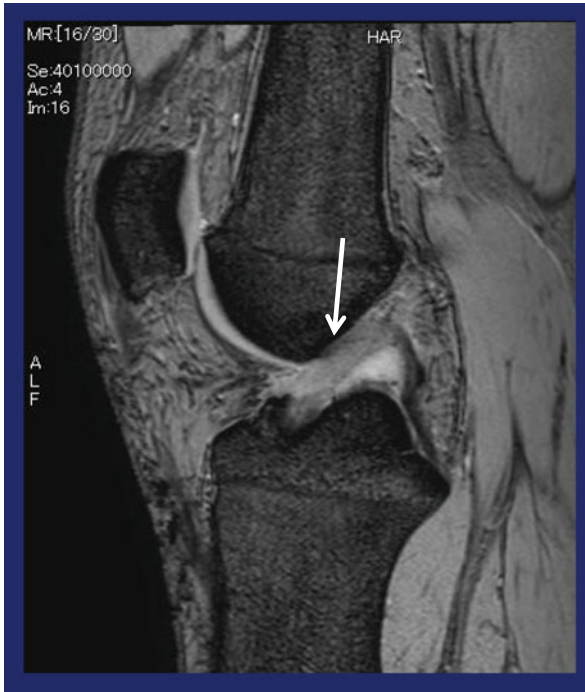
An example of 1-year-old ART BTB ACL graft shown in T2-weighted sagittal MR image. The graft is running along the Blumensaat's line like the native ACL in extension, while the femur-tibia relationship is normally maintained
